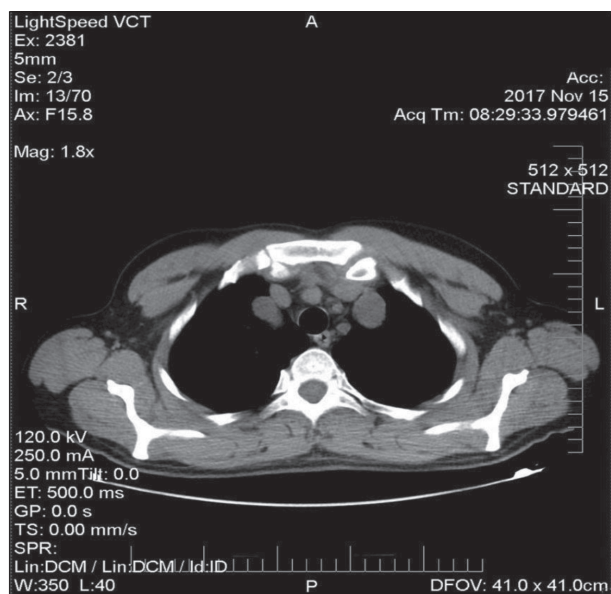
Chest computed tomography showing bilateral nodules
